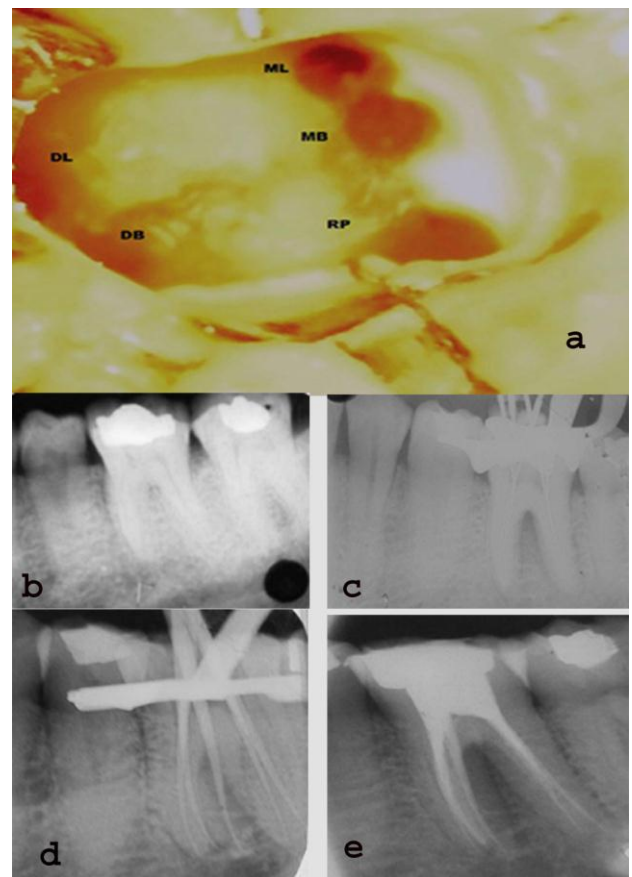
(a) clinical image of the opening cavity to reveal the orifice of the radix paramolaris (MB mesiobuccal; DB distobuccal; DL distolingual; ML mesiolingual; RP, radix paramolaris). (b) Preoperative radiograph. (c) Length determination. (d) Gutta cone fit. (e) Postoperative radiograph.
